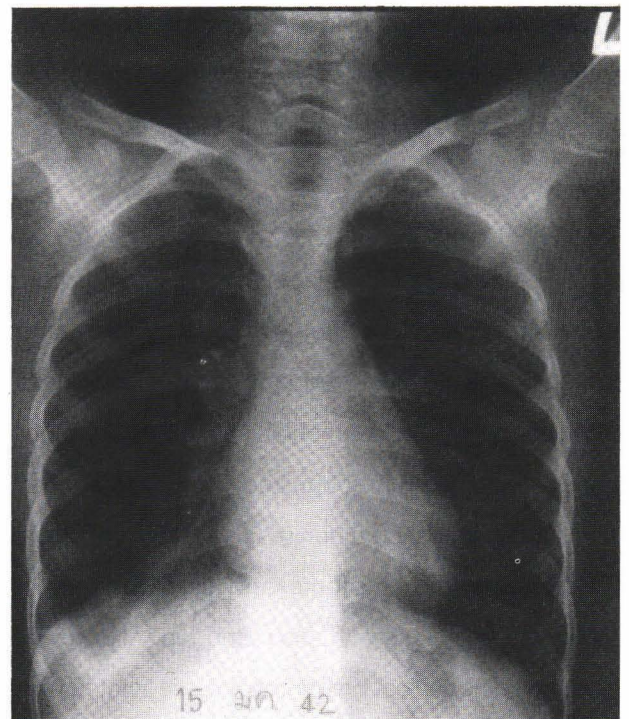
Chest radiograph demonstrates minimal reticular infiltration in the right lower lung with minimal right pleural effusion.
